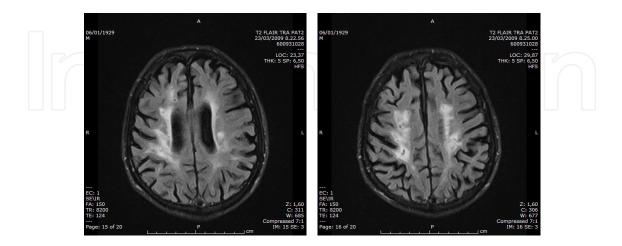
Brain MRI (FLAIR sequences) of a 80 years old man with a multi-infarct progressive dementia with bulbar symptoms. Multiple cortical and subcortical infarct are seen together with periventricular white matter changes and corticola atrophy.
